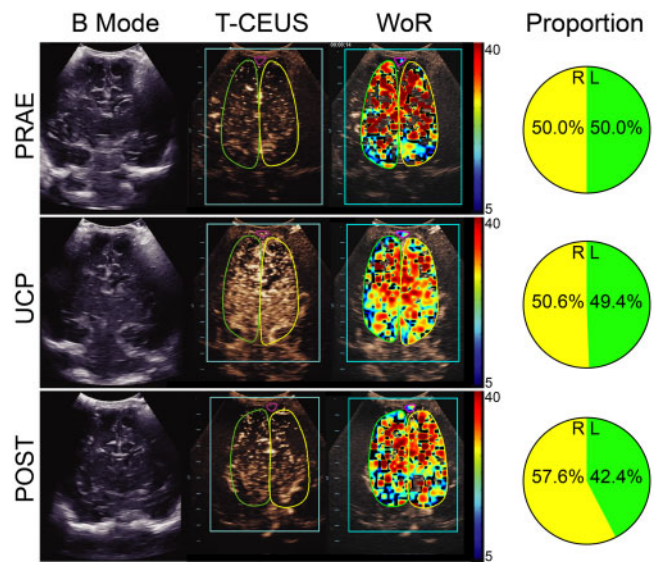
Quantification and analysis of T-CEUS parameters. From left to right: B Mode ultrasound (B Mode) for anatomical identification, contrast-enhanced ultrasound of microbubble signals, WoR as quantified colour-coded parameter, and proportion of signal distribution for each hemisphere. Note the homogeneous distribution of T-CEUS signal during preoperative and UCP in contrast to postoperative state. POST: after skin closure; PRAE: before skin incision; T-CEUS: transfontanellar contrast-enhanced ultrasound; UCP: unilateral cerebral perfusion; WoR: wash-out-rate.
